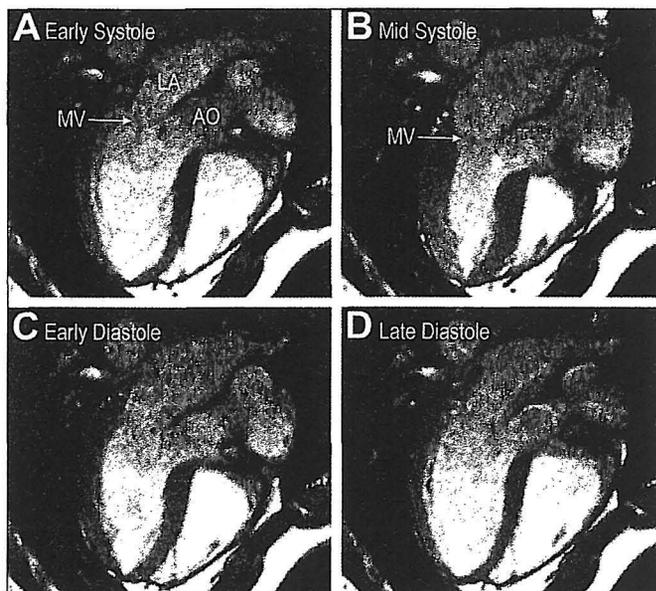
Four still frames from a representative magnetic resonance imaging movie (available at: <http://www.euronet.nl/~denham/MRI-movies>). LA=left atrium; MV=mitral valve; AO=aortic valve; LV=left ventricle. Reproduced with permission from *Heart Rhythm*. 2005;2:188–196.²
